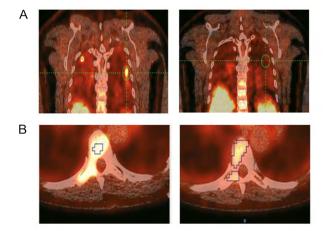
A: Pulmonary metastasis of sarcoma patient at baseline (A, left) and after 8 weeks of anti-angiogenesis treatment (A, right): this particular lesion cannot be included according to PERCIST, as its FDG-avidity is too low at baseline, although response during follow-up seems obvious
